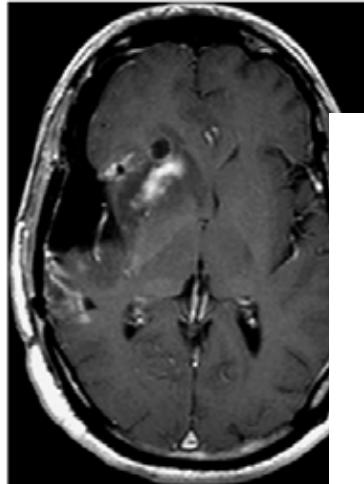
Axial T1-weighted MR image with gadolinium obtained 5 months after re-resection demonstrating enhancement indicative of progression despite T chemotherapy. A small cystic region is seen anterior.
